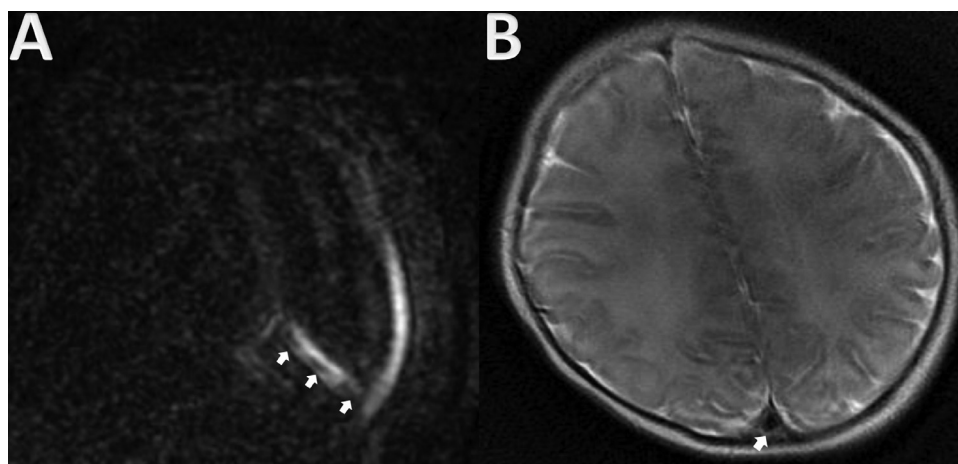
A. Sagittal non-contrast Magnetic Resonance Venography Inhance 3D Velocity image showing lack of flow in the connection of right transverse sinus and confluence sinuum (arrows). B. Axial T2-weighted image Magnetic Resonance image showing partially absence of flow in the right transverse sinus causing peripheral narrowing of the vein lumen (arrow)
